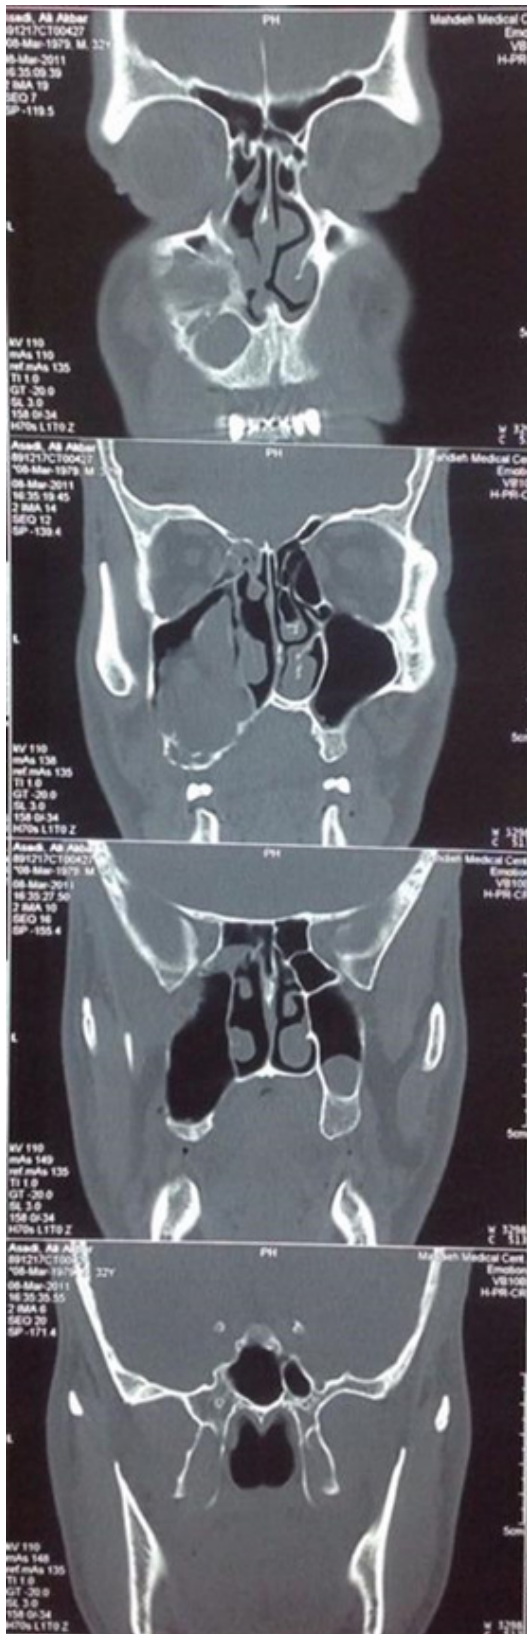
CT scan showing maxillary sinus
